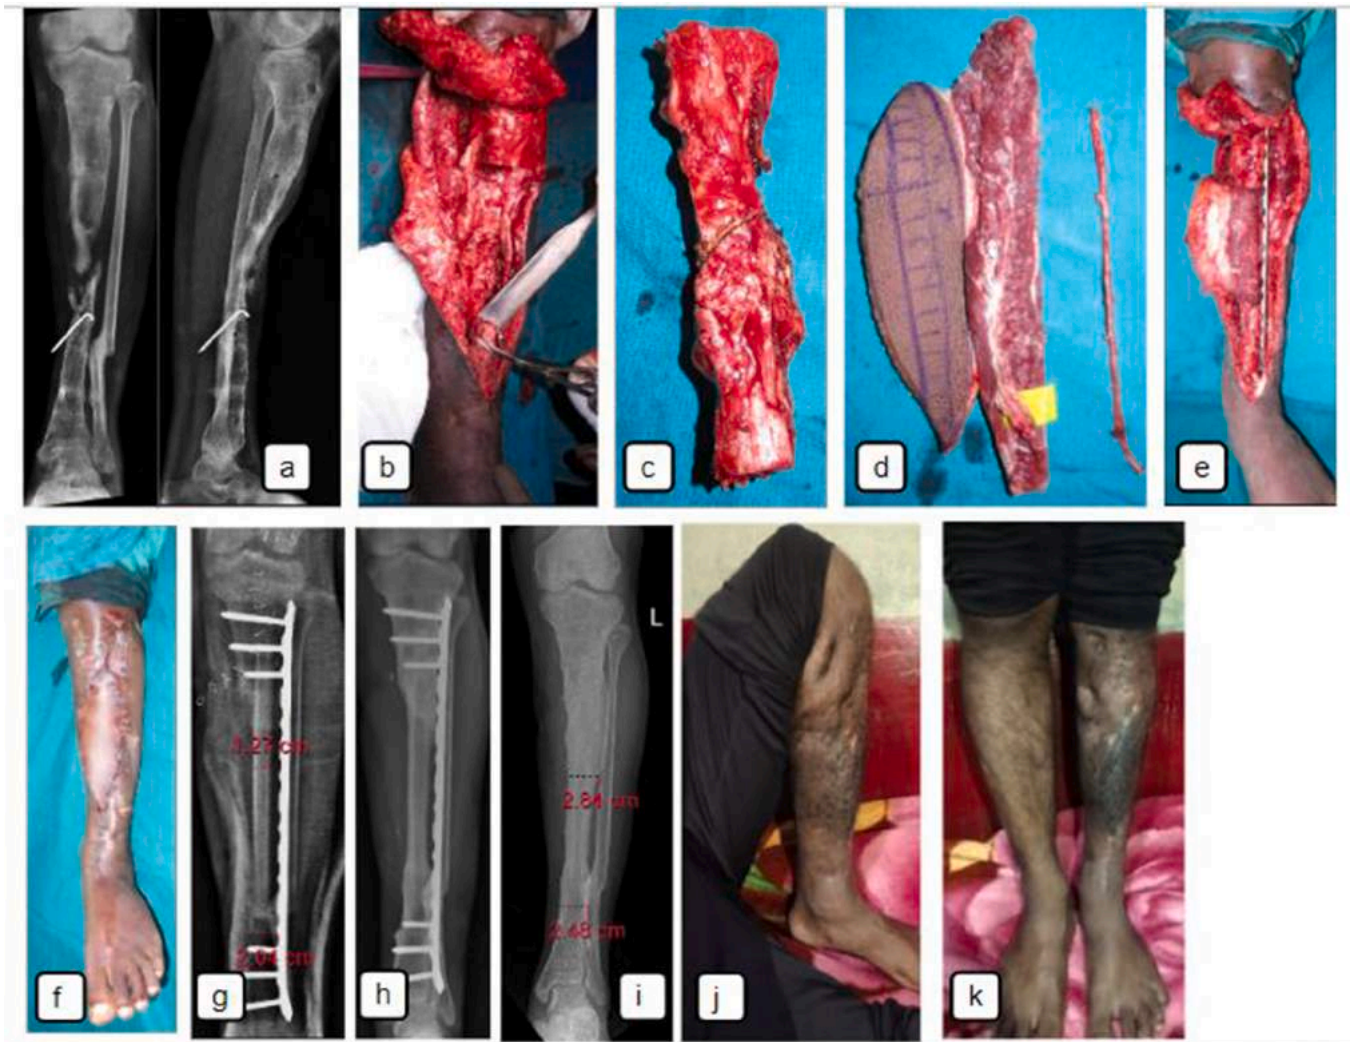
(a)- Case of a young male with an infected nonunion with sclerotic bone ends, (b& c)- Resection of avascular bone ends till bleeding edges, (d)- harvested free fibula with skin paddle and vein graft for anastomosis, (e)- Fixation of free vascularized fibular graft with 4.5 locking plate, (f)- Suturing of skin paddle to the recipient skin, (g & h). Progression of hypertrophy, (i) X-ray showing complete union and 142 % graph hypertrophy at the end of 36 months and implant removal (j & k)- Clinical pictures showing good range of motion and no length discrepancy.
